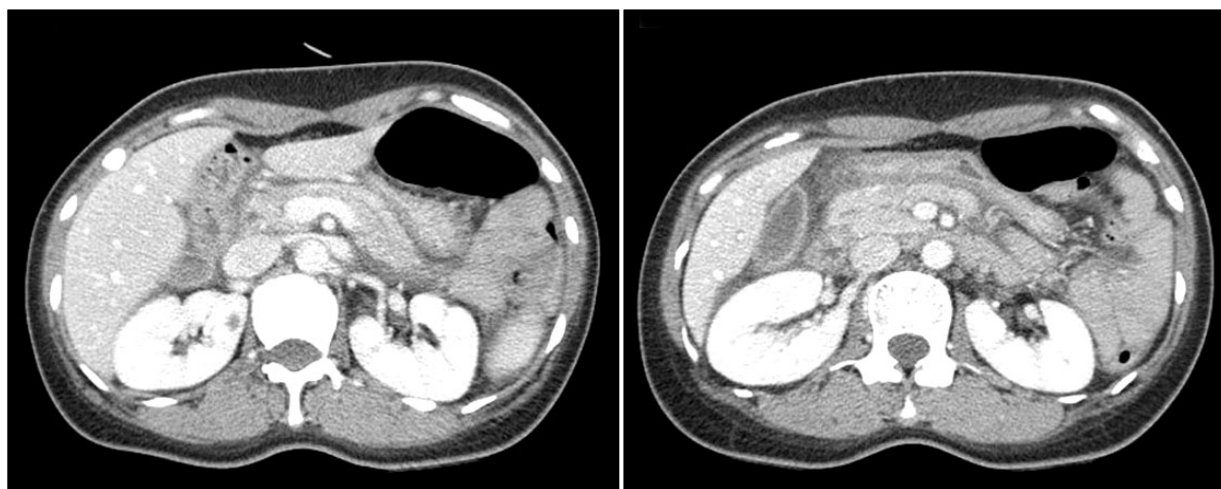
CT scan revealing diffuse swelling of the pancreas with peripancreatic fat infiltration and a small amount of fluid collection. CT, computed tomography.
